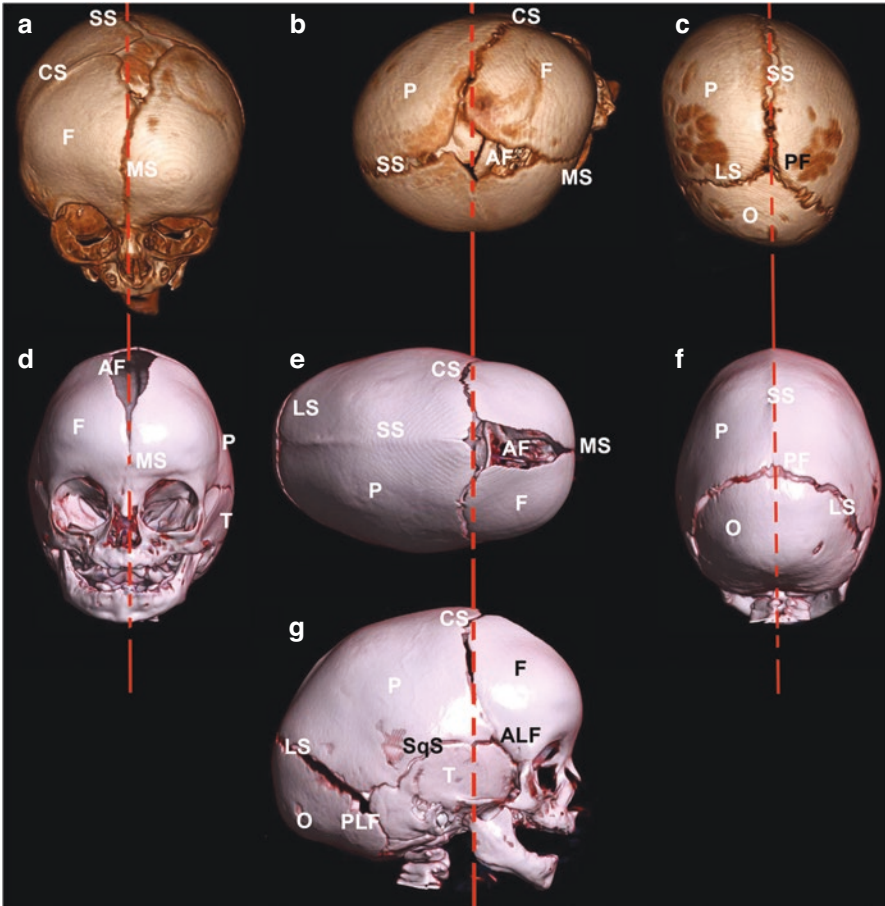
CT 3D reconstructions of newborns with cranial suture and ossification anomalies. (a–c) Premature closure of right part of the coronal suture in 6-month-old child. (d–g) Premature closure sagittal suture in 4-month-old child. (Courtesy of Dr. Saim Kazan). Abbreviations: AF: Anterior fontanelle, ALF: Anterolateral fontanelle, CS: Coronal suture, F: Frontal bone, FC: Falx cerebri of cranial dura mater, LS: Lambdoid suture, MS: Metopic suture, O: Occipital bone, P: Parietal bone, PF: Posterior fontanelle, PLF: Posterolateral fontanelle, Red lines: Orientation lines for sutures, SqS: Squamous suture, SS: Sagittal suture, T: Temporal bone
